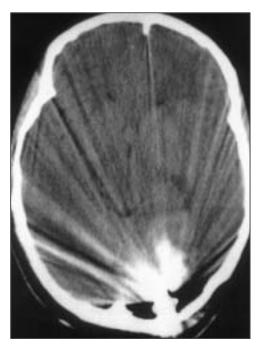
CT scan at the third day showing a backwards migration of the bullet, located adjacent the inner table of the left occipital vault.
